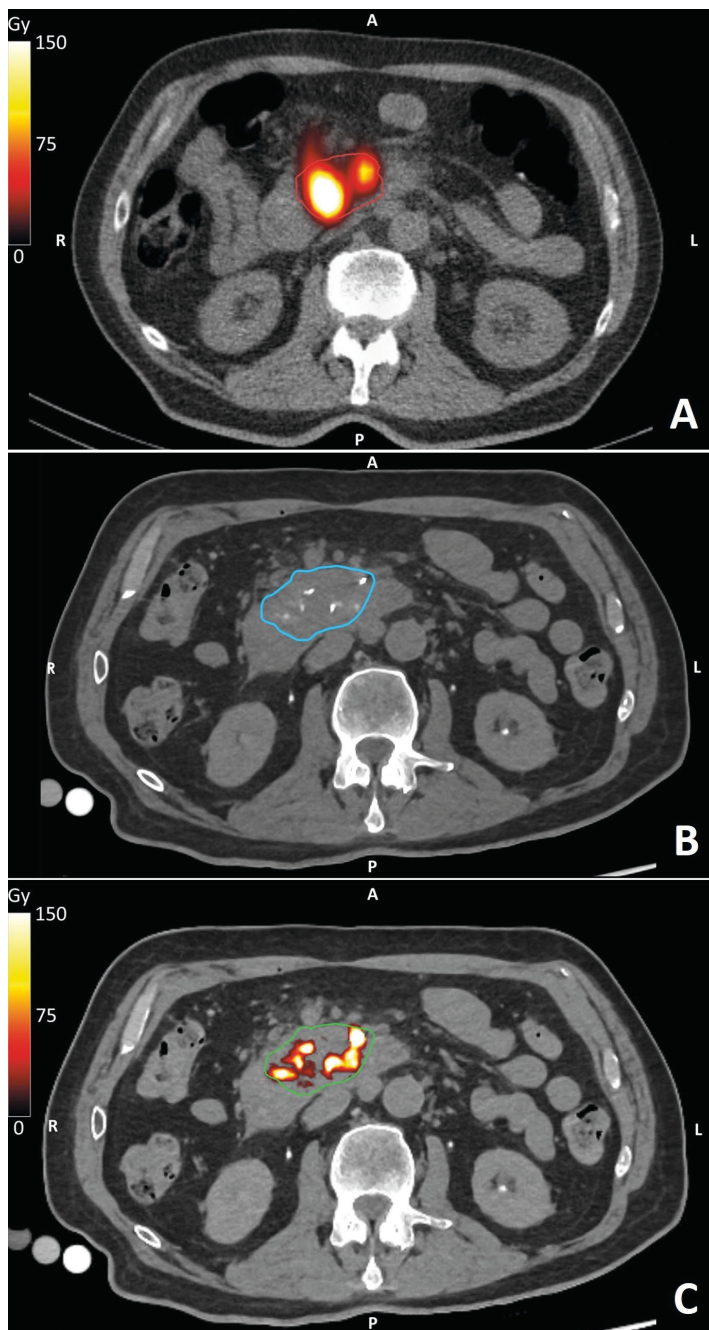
Image overview showing the distinction between SPECT and CT imaging, and quantification in the same patient and position (patient 2). (A) Postprocedural SPECT dose map (Gy) showing the irradiated area in red, yellow, white within the tumor, outlined in red. (B) Periprocedural CT with hyperdense holmium-166 microsphere deposits within the tumor, outlined in blue. (C) Postprocedural CT dose map (Gy) showing the irradiated area in red, yellow, and white within the tumor, outlined in green.
